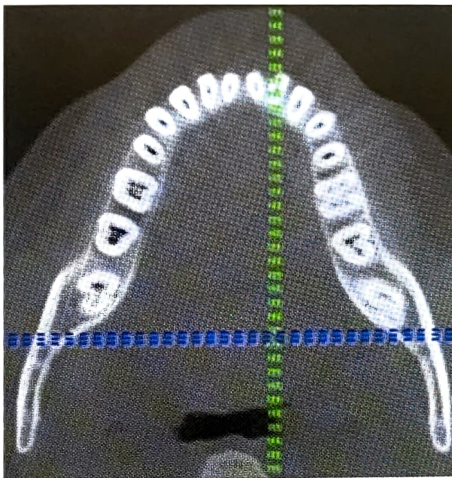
CBCT demonstrates axial 2-D slices of 36 showing extra root; Coronal third
